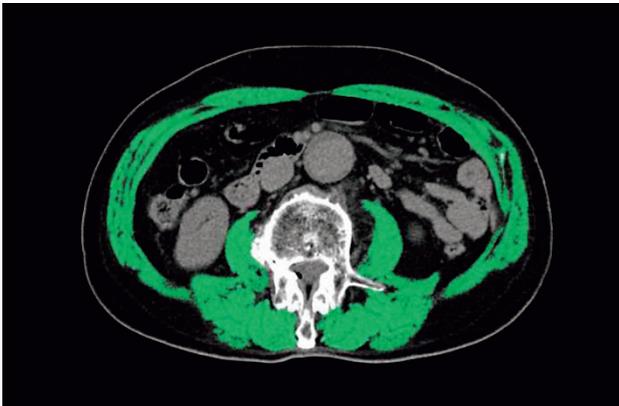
CT scan of the L3 region showing the total skeletal muscle mass (green).
